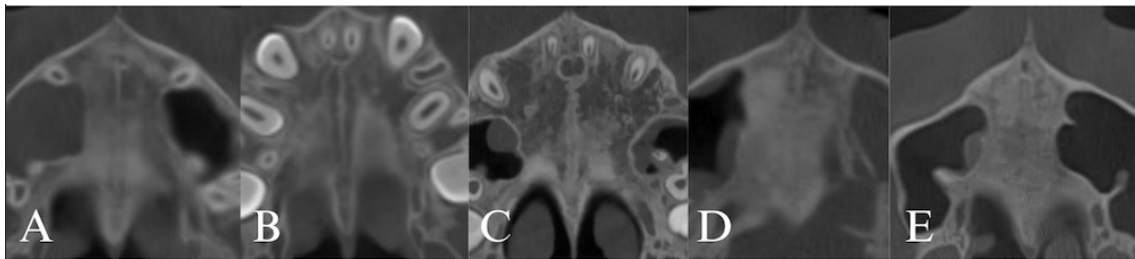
The classification of MPS stages A to E according to its morphology, visible on the CBCT axial cross-sectional slices.
